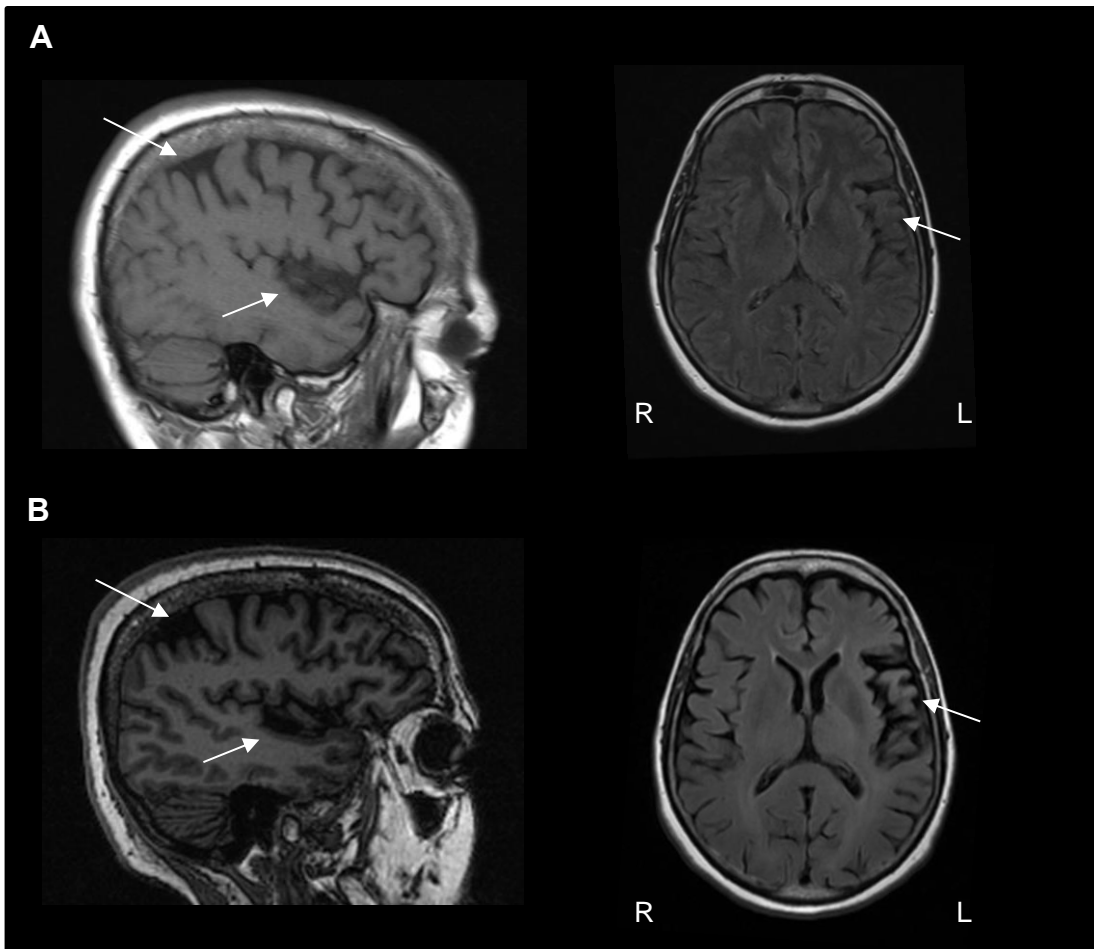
Figure e-2. Baseline and follow-up brain MRI of a patient with pure lvPPA. A: patient #25 at age 63, one year from onset (sagittal T1 and axial FLAIR sequences). B: patient #25 at age 66, four years from onset (sagittal T1 and axial FLAIR sequences). Progression of atrophy in left parietal and superior temporal cortex (arrows).
